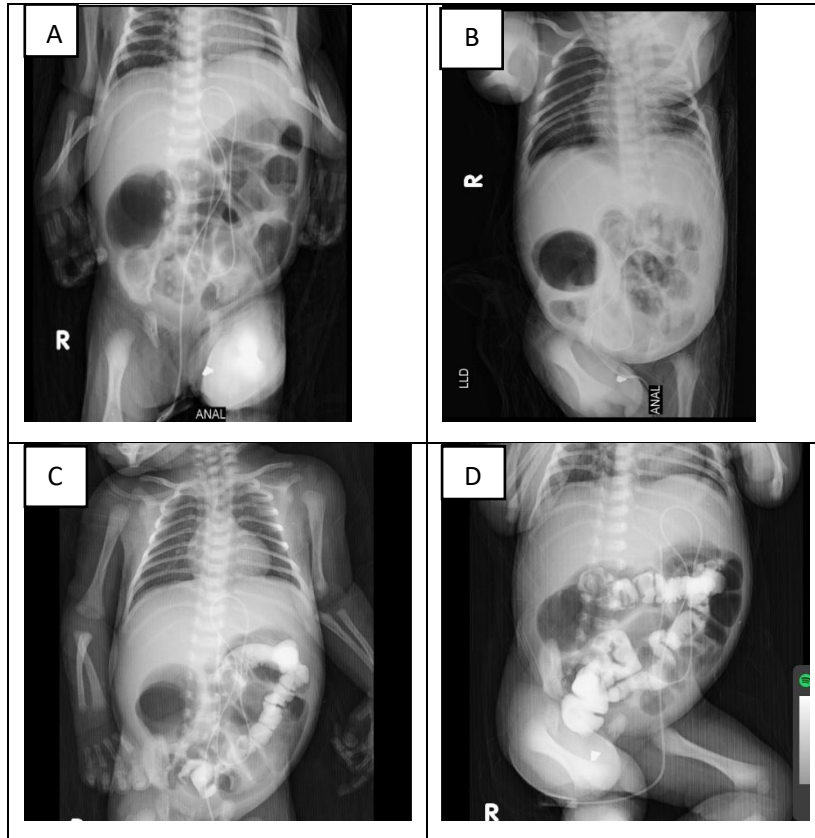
A. Plain supine position X-ray, B. Plain LLD position X-ray, C. Colon in loop, Contrast is seen filling the rectum, sigmoid colon, descending colon, splenic flexure, and part of the transverse colon. D. Colon in loop, Narrowing of the rectal lumen, and dilation of the sigmoid colon are observed.
